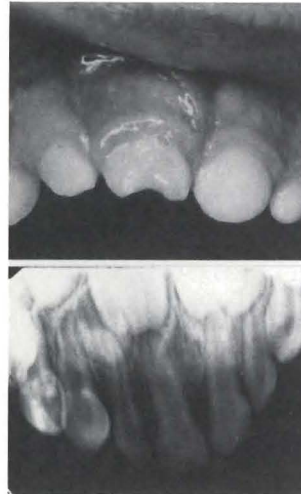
Clinical observations: R.P., three-year-old boy struck tooth E on a metal chair, a week earlier. Tooth E was mobile, grey-black, sensitive to percussion and palpation. Class II Ellis fracture and swollen labial gingiva as shown in the clinical photograph. Radicular fracture and periapical radiolucency seen on radiograph. The tooth was extracted seven days after injury.
